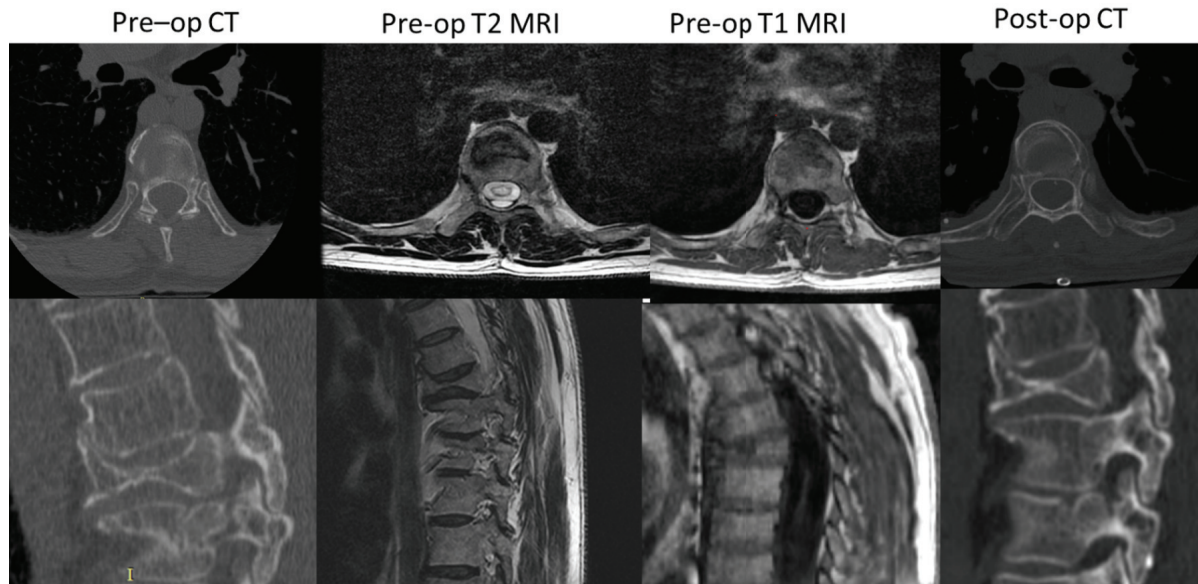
Patient 1: Clinical course – Patient with expansile cyst extending from T5 – T11 as visualized on axial and sagittal CT, T2-MR, and T1-MR. Postoperative changes seen on CT.
